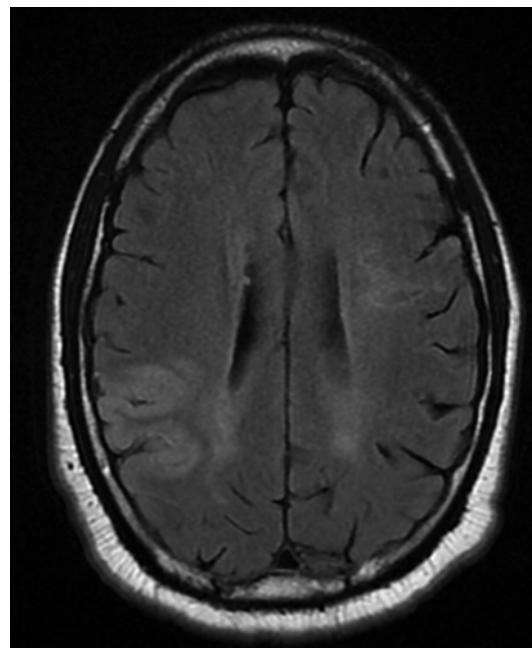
MRI brain showing multiple strokes, likely of embolic origin.
